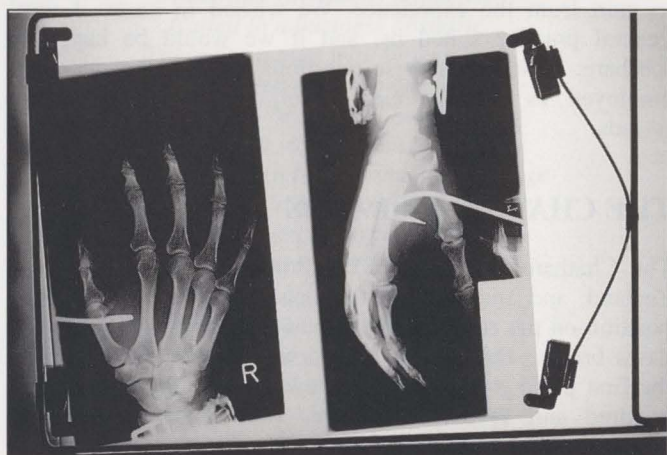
X-ray and photo of hand
